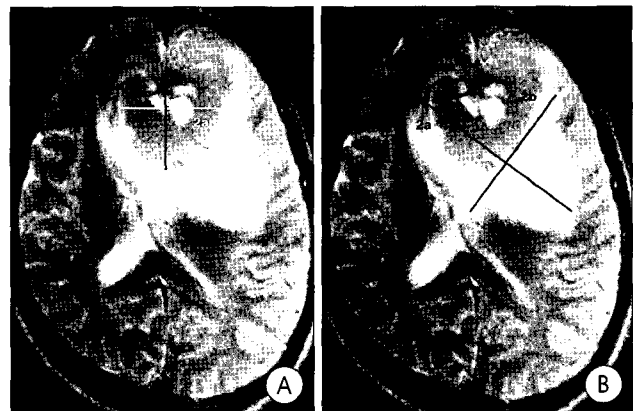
A : Tumor volume (V_t) was measured from MR image, maximal perpendicular diameters (radii a and b) of the tumor. Coronal diameters of the tumor was approximated by coronal section images showing tumor tissue (radius c, not shown here). B : The resulting volume of tumor and edema (V_{t+e}) was then approximated using the formula for a spheroid : ($V = 4/3 \pi \times abc$). Edema index (E) = $(V_{t+e})/(V_t)$.
